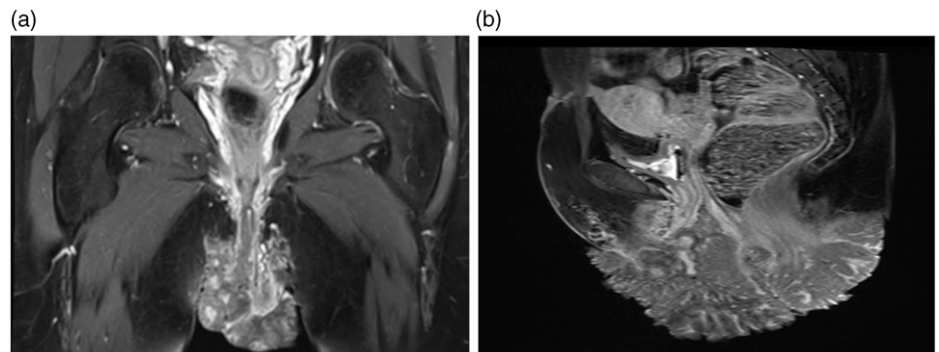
(a, b) Coronal and sagittal section of MRI showing massive exophytic lesion over vulva.
